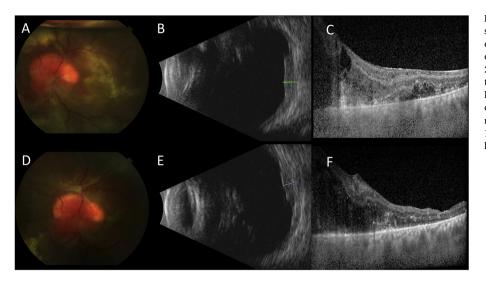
Case 1. Fundus photography (A) demonstrating juxtapapillary hemangioblastoma with overlying fibrosis/gliotic retina, corresponding with elevated placoid mass on ultrasound measuring 2.1mm in height (B) and corresponding foveal optical coherence tomography (C). One-month following three infusions of bevacizumab devliered via ophthalmic artery chemosurgery, the fundus remained stable (D) and tumor height decreased to 1.8mm (E) with post-treatment foveal optical coherence tomography (F).
